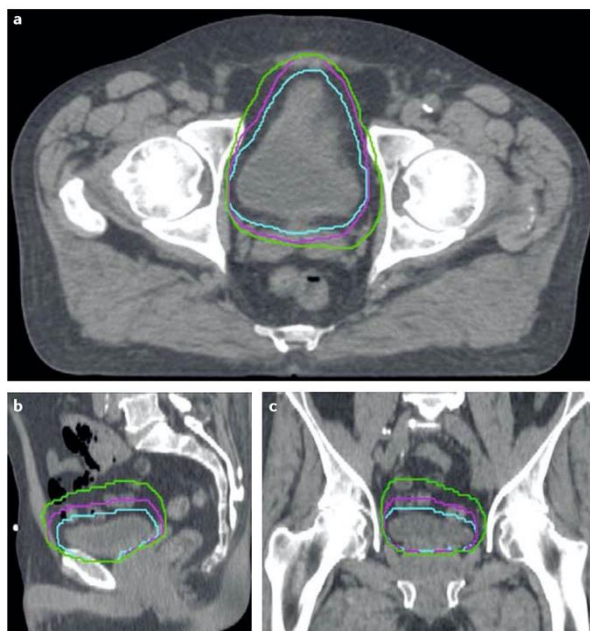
Adaptive radiotherapy with the POD strategy. The axial (part a), sagittal (part b) and coronal (part c) CT images show the clinical target volume (CTV) plans for the 'plan of the day' (POD) adaptive bladder radiotherapy strategy. The initial treatment planning CT scan is modified to generate three isocentrically grown CTV plans — a small (blue), medium (purple) and large (green) plan. Before each day's radiotherapy treatment, a cone-beam CT scan is performed and the most suitable CTV plan that provides the best target coverage and the lowest dose to organs at risk is selected.
